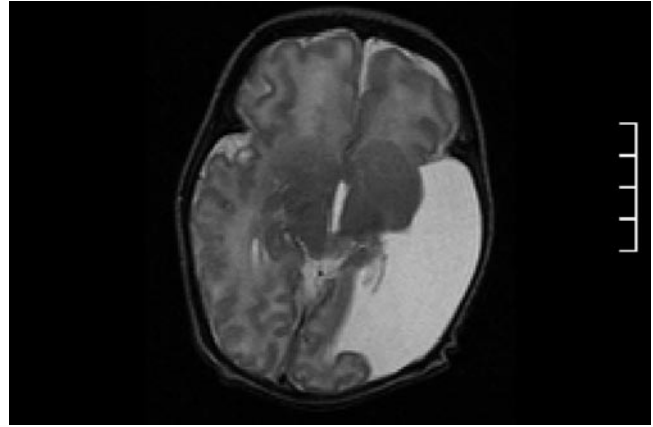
Axial postnatal MRI demonstrating left sided cystic mass.
